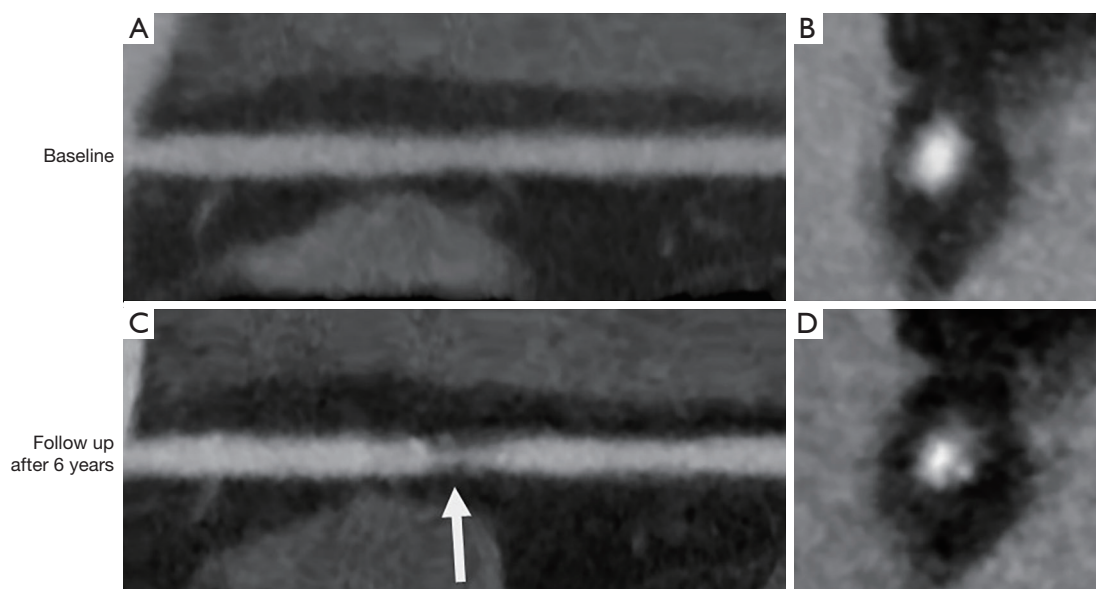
A case of normal coronary artery that progressed to significant stenosis after 6 years. Stretched MPR CT angiographic (A) and corresponding axial (B) CT images of a 38-year-old male reveal normal RCA with no atherosclerotic disease or stenosis at baseline (CAD-RADS category 0). After 6 years, stretched MPR CT angiographic (C) and corresponding axial CT (D) images show a focal plaque (arrow) with small calcification at the proximal RCA that is causing severe luminal stenosis (CAD-RADS category 4, 70–99%). No other lesion was identified. He did not have previous history of hypertension, diabetes, dyslipidemia, stroke or ischemic heart disease, and has smoked for 10 years. MPR CT, multi-planar reformatted computed tomography; RCA, right coronary artery; CAD-RADS, Coronary Artery Disease Reporting and Data System.
